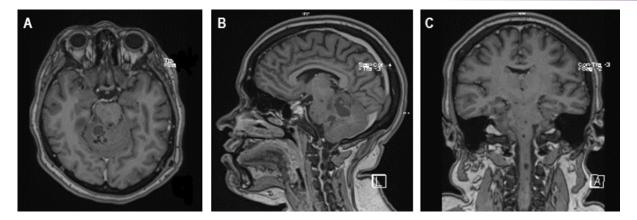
Contrast enhanced T1-weighted images, showing enhancement of cerebellar lesion (A, B) and presence of multiple lesions involving the brainstem and cervical spinal cord (C).
